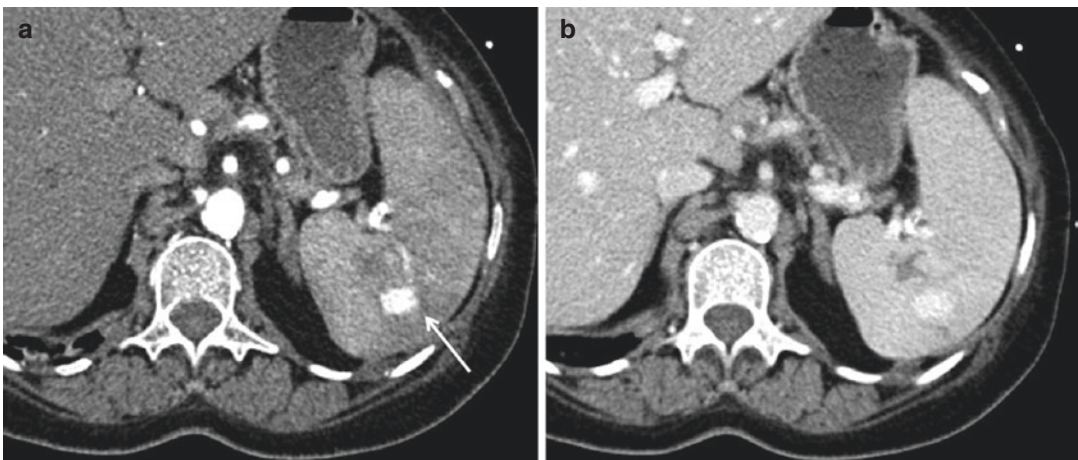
Grade 4a: These arterial (a), and venous (b), axial CT images show a pseudoaneurysm (*arrow*) associated with a splenic parenchymal laceration: in this case, a vascular study is essential as it allows to make a differential diagnosis between active bleeding and a contained vascular lesion (such as pseudoaneurysm and arteriovenous fistula). On single-phase scanning, it can be difficult
